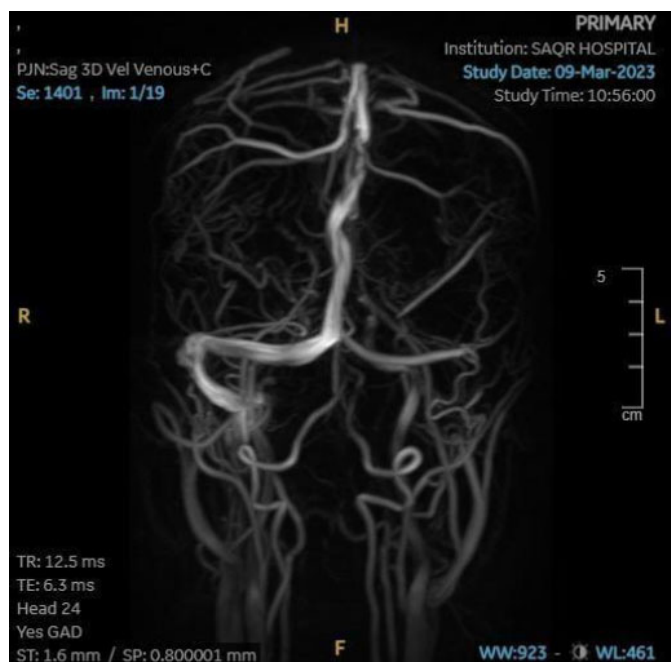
Enhanced MRI and MRV examination of the brain result of the patient in follow-up showing remarkable regressive course regarding the extent of the previously depicted intraluminal sizeable filling defect within left sigmoid venous sinus and scanned left internal jugular vein only remaining minute intraluminal filling defect within left sigmoid venous sinus in the current study.
